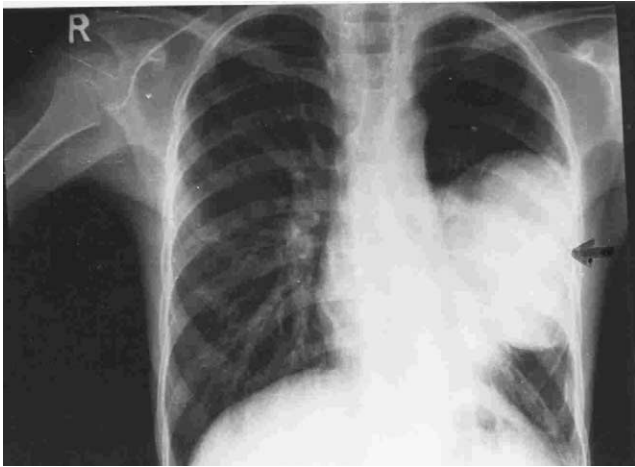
Chest X-ray showing well defined paracardiac mass.
